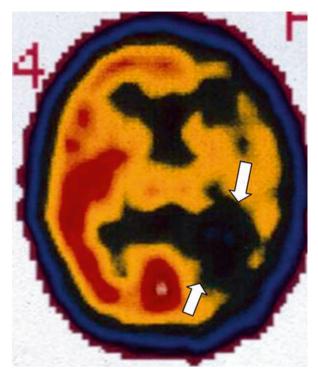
Brain SPECT done the day after admission showing decreased radionuclide uptake in left hemisphere, predominantly in its posterior areas (*arrows*)
